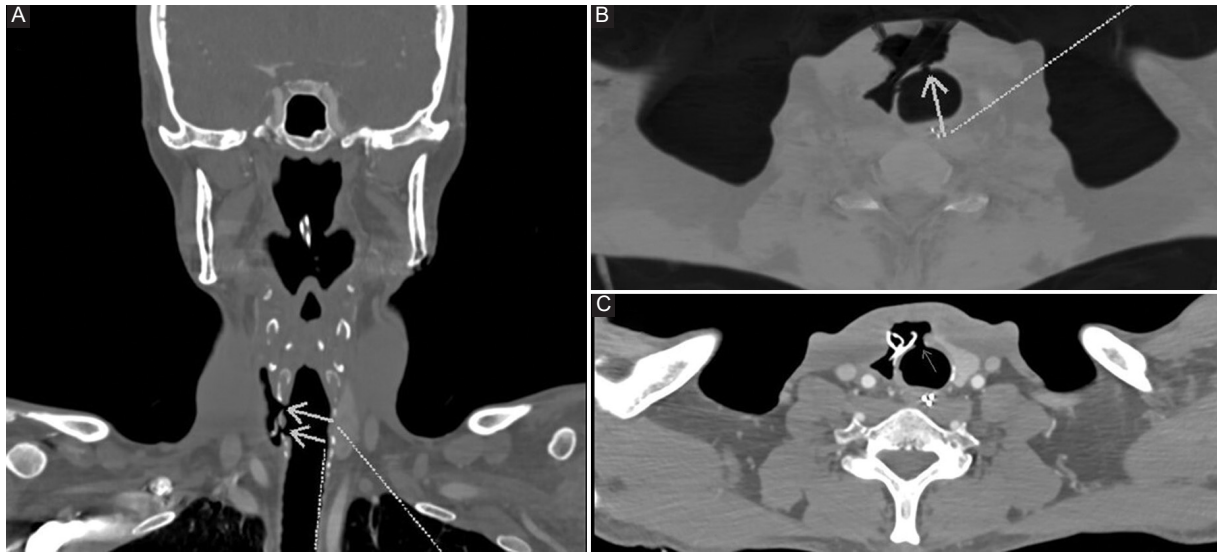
A: coronal section of computed tomography (CT) scan showing 2 defects in the tracheal wall communicating with an air collection. B: axial section of CT scan also showing 2 defects in the tracheal wall. C: axial section of CT scan showing a defect in the tracheal wall communicating with a collection after placing a Penrose drain inside.
